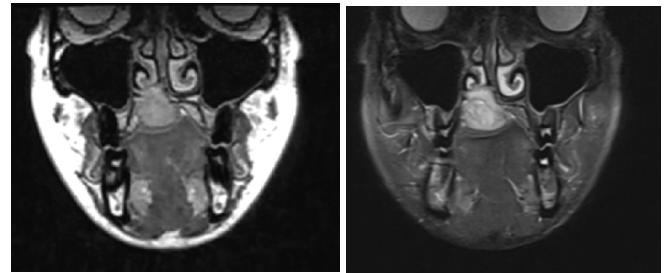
MRI 1,5T T1 and T2.
